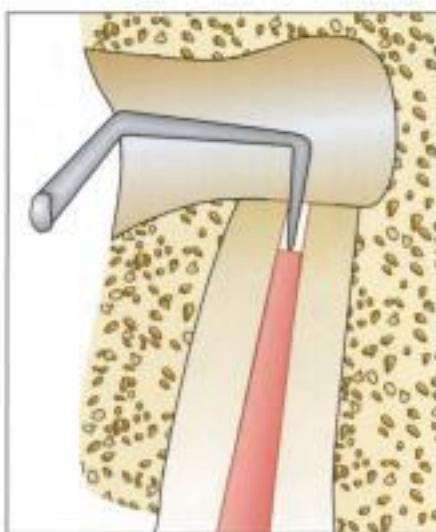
Retrograde cavity preparation using ultrasonic handpiece
